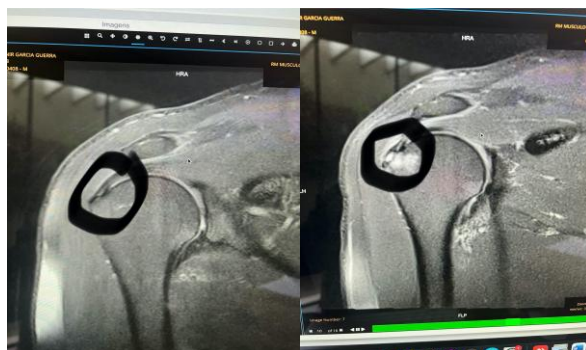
MRI comparison. Left – Follow-up MRI showing tendon healing. Right – Initial MRI showing high-grade partial tear.
